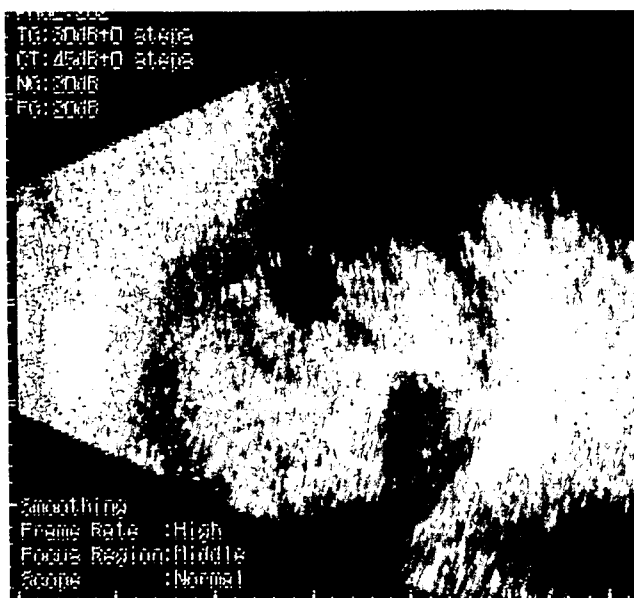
Ultrasound echogram of case 1. Echogram showing high signals from the vitreous body indicating intravitreal asteroid bodies. Interestingly, the signals are reduced in the area of the vitreomacular attachment (arrow) showing low-echo space, suggesting an incomplete posterior vitreous detachment
